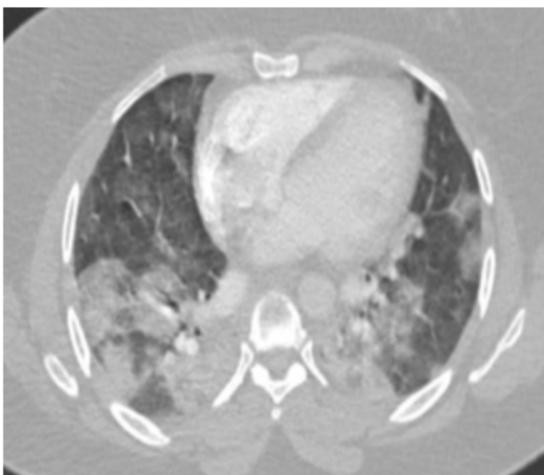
Lung window of case 2 showing features of atypical pneumonia with CT severity score 15/25. CT pulmonary angiography non enhancing filling defect is seen in segmental branch of right ascending and left descending pulmonary artery
